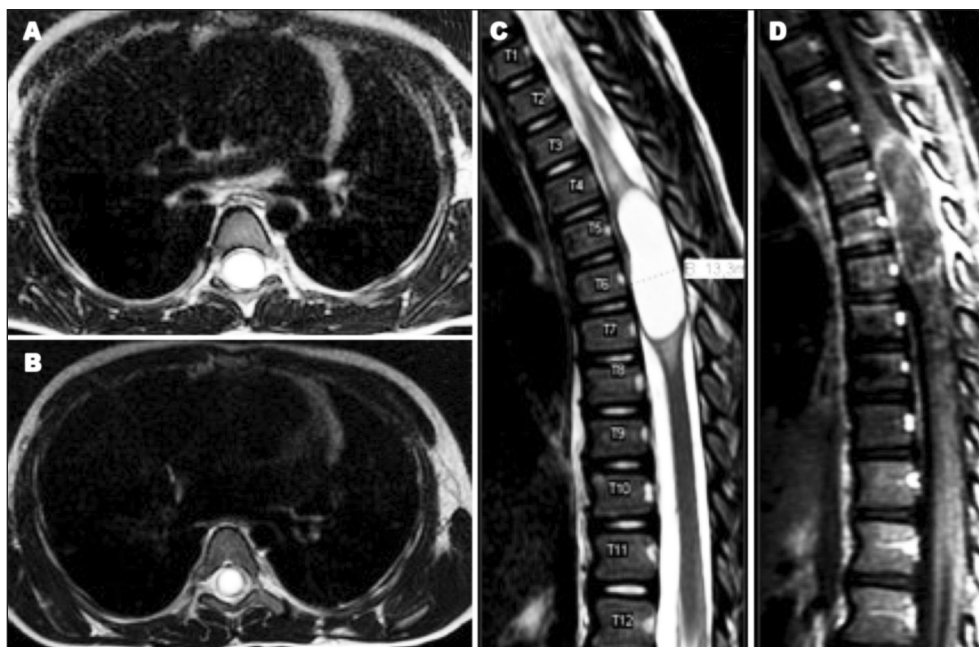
MRI showing high signal lesion on T2, extending from T5–T7 [A, B and C]. T1 after gadolinium shows heterogeneous enhancement [D].
